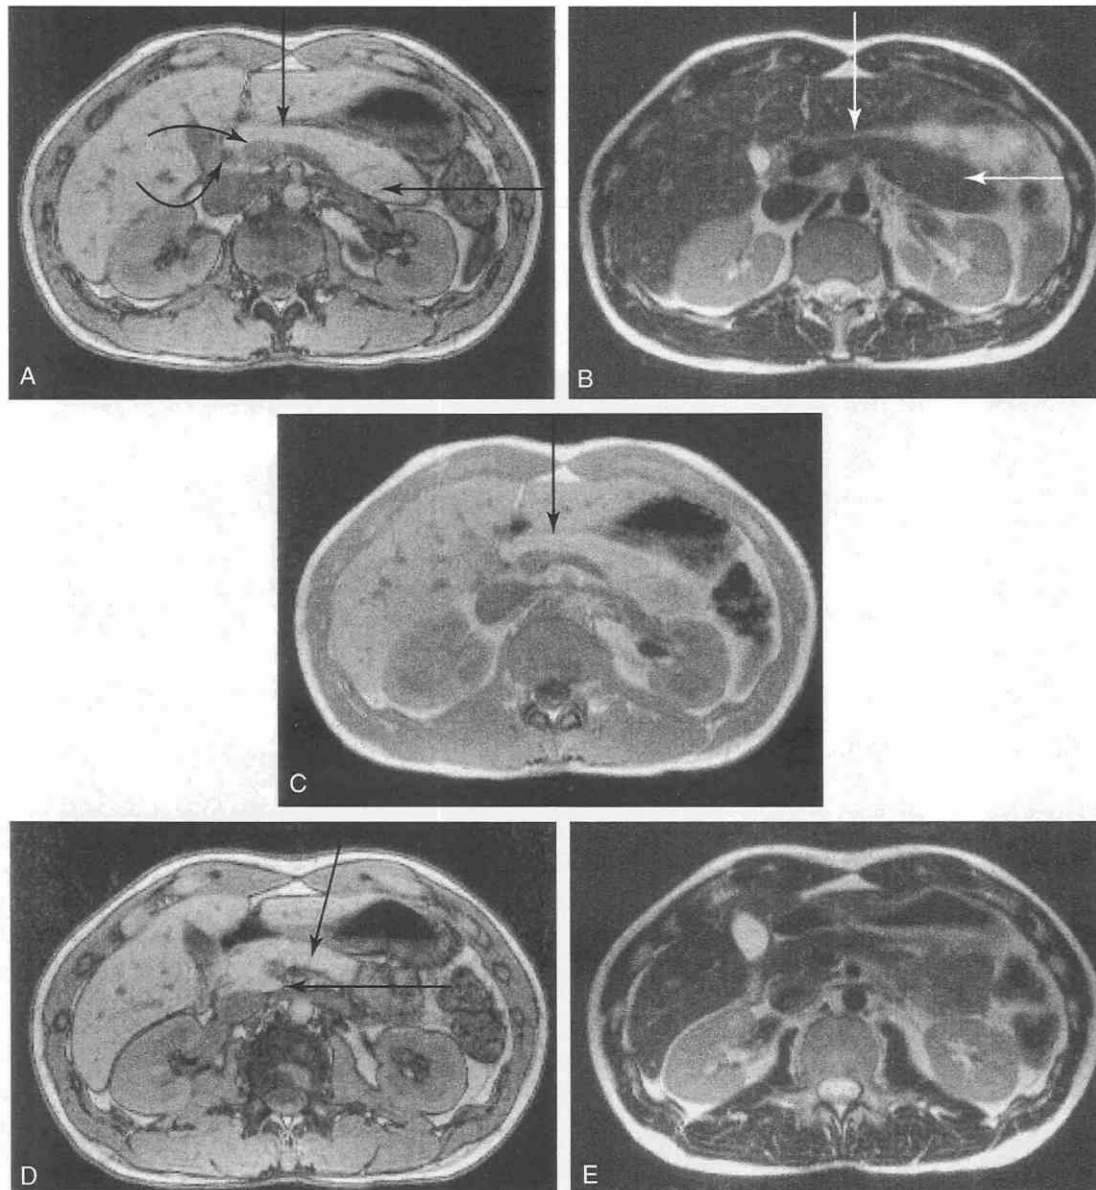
Normal-appearing gland with various pulsing sequences; see MRI section for specific technique. *A*, Normal gland, T1 weighting out of phase, shows discrete gland with the neck portion (*vertical arrow*) and tail of gland (*horizontal arrow*). The portal vein (*large curved arrow*) is seen behind the head, and the common bile duct (*small curved arrow*) is seen. *B*, Same slice with in-phase T1. Note the change in the visualization in the margins of the organs. The neck (*vertical arrow*) and tail (*horizontal arrow*) are again seen. *C*, Appearance of the gland during T2-weighted sequences. Note the effects of the change in sequence on the delineation of the margins of organs. *D*, Lower axial slice in same patient shows segment of the uncinus portion (*horizontal arrow*) of the gland behind the superior mesenteric artery, with T1 weighting out of phase. The neck (*vertical arrow*) is again seen. *E*, Lower axial slice with T2 weighting in the region of the head; compare with *D*.
